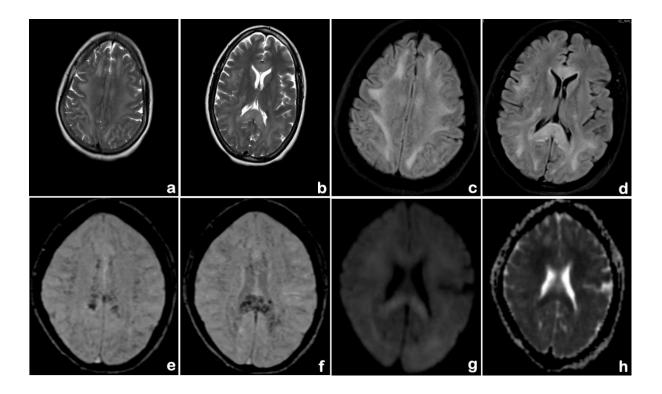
Axial T2 weighted (a, b) and FLAIR images (c, d) show symmetric, confluent hyperintensity involving the subcortical white matter in the frontal, parietal and occipital lobes extending across the genu and splenium of the corpus callosum. Hyperintensity is also noted in the posterior limb of the internal capsule on both sides. Multiple microbleeds are seen in the subcortical white matter and splenium of the corpus callosum on axial susceptibility weighted images (e, f). Diffusion weighted trace image (h) and corresponding ADC map (g) show diffusion restriction across the splenium of the corpus callosum. These imaging findings are typical of high-altitude cerebral edema in the appropriate clinical setting.
